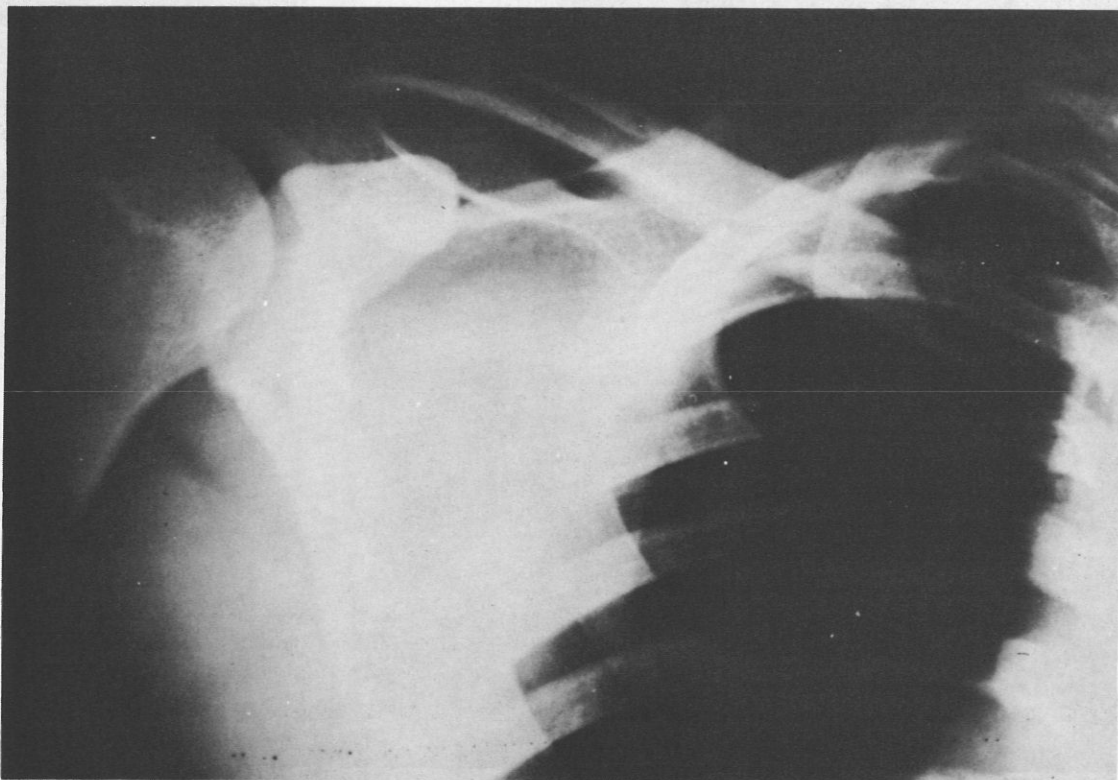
AP X-ray study of the clavicle reveals a stress fracture of the middle third.
